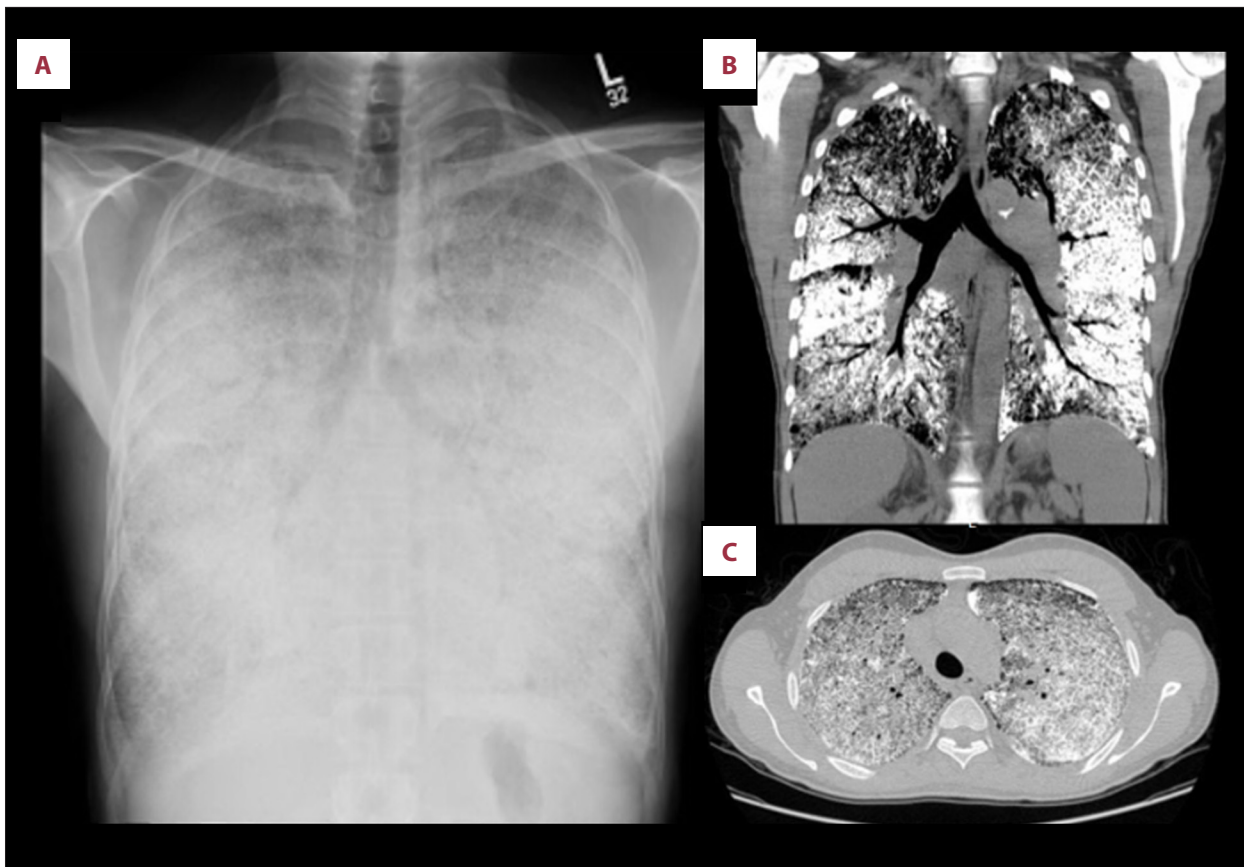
Shows diffuse opacification on chest, which appears dense; the appearance is compatible with pulmonary calcinosis. The visualized bony thorax appears grossly unremarkable on X-ray (A). CT scan shows diffused opacification of both lungs, with calcific densities involving the entire lungs. The calcific densities predominantly involve the middle lobe and lingula more extensively. The tracheobronchial tree appears grossly unremarkable. There is enlargement in the pulmonary trunk, compatible with pulmonary hypertension (B, C).
